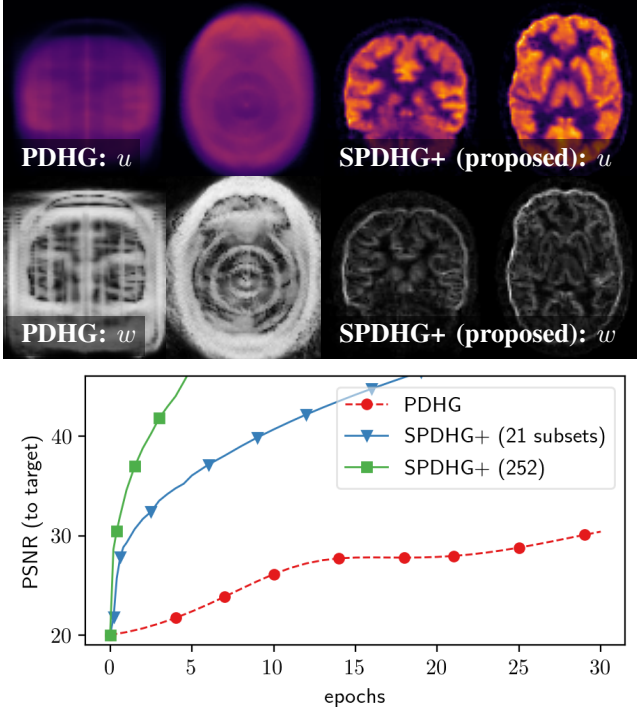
TGV regularized reconstruction for the FDG data. The qualitative top and quantitative bottom results show that only a few epochs are needed to reconstruct clinically relevant images if randomization and preconditioning are used. This is visible for both the actual images u and for the reconstructed vector field w .
